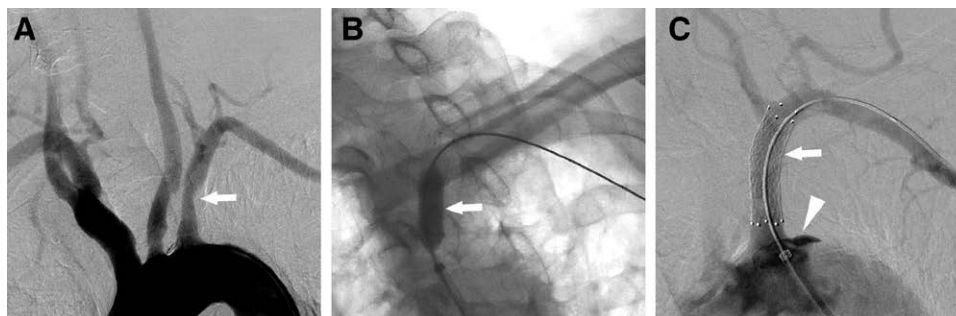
A–C, PTAS for stenosis of the left SA complicated by type B aortic dissection. This 85-year-old gentleman had dizziness for 3 months. He underwent sonography, which showed biphasic flow of the left vertebral artery. The angiogram showed 60% stenosis of the left proximal SA (A, arrow). We first deployed a 9 × 30 self-expandable Epic stent in the left proximal SA and performed angioplasty with an 8 × 20 mm Wanda balloon (B, arrow). The control angiogram showed focal dissection in the descending aorta (C, arrowhead). PTAS = percutaneous transluminal angioplasty and stenting; SA = subclavian artery.
